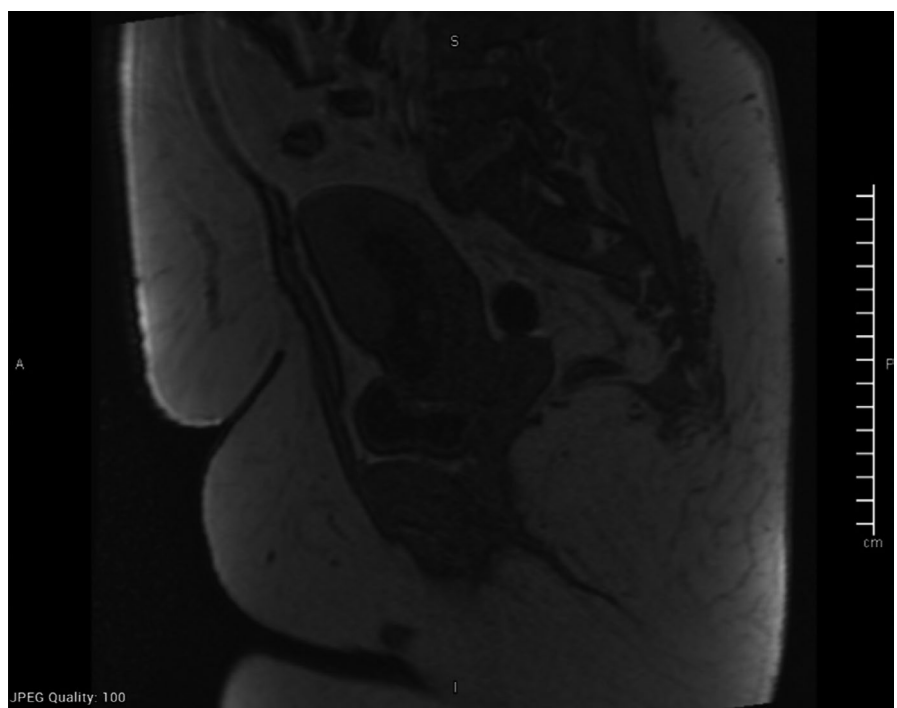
T1 MRI image showing a viable gestational sac lowly implanted and seen bulging in the previous LSCS scars region
